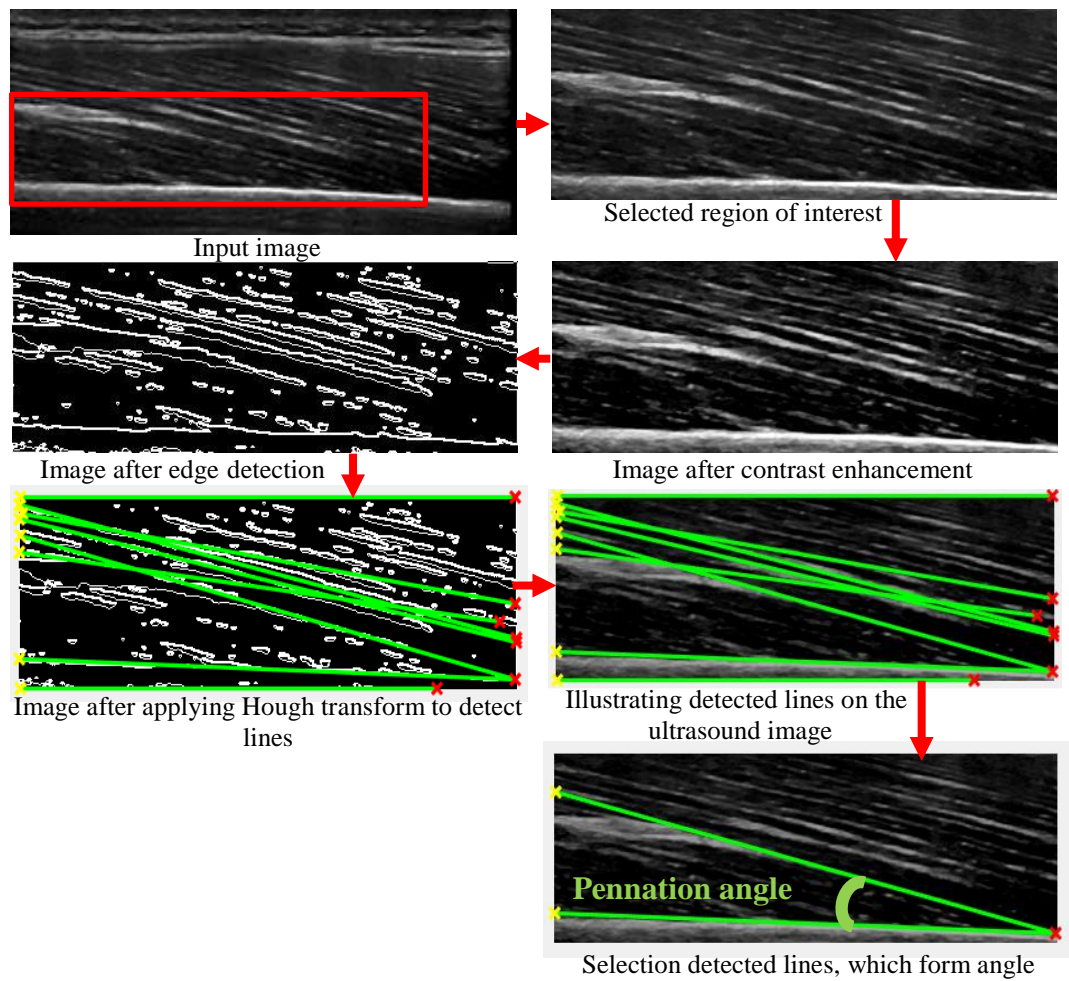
presents the steps of the pennation angle evaluation of the triceps muscle in one snapshot ultrasound image, the pennation angle is taken as the angle between the aponeurosis and the fibre direction.
